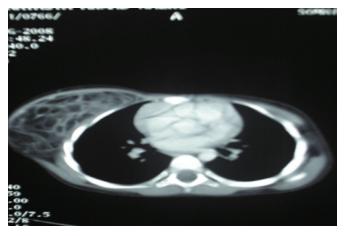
Computed tomography scan showed a hypodense lesion suggesting presence of fatty components with multiple septate, suggestive of lipoblastoma.
